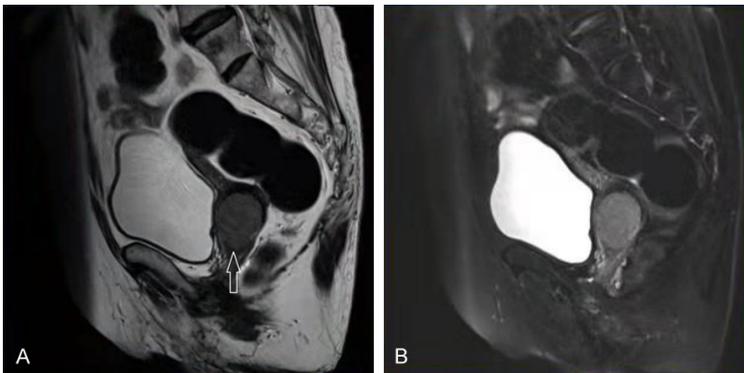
Typical MRI images from a cervical cancer patient. Note: (A) A sagittal SET1 weighted image in which a massive and long T1 signal occupying lesion can be seen in the uterine neck; (B) A sagittal SET2 weighted image, and a massive long T2 signal occupying lesion can be seen in the uterine neck.
